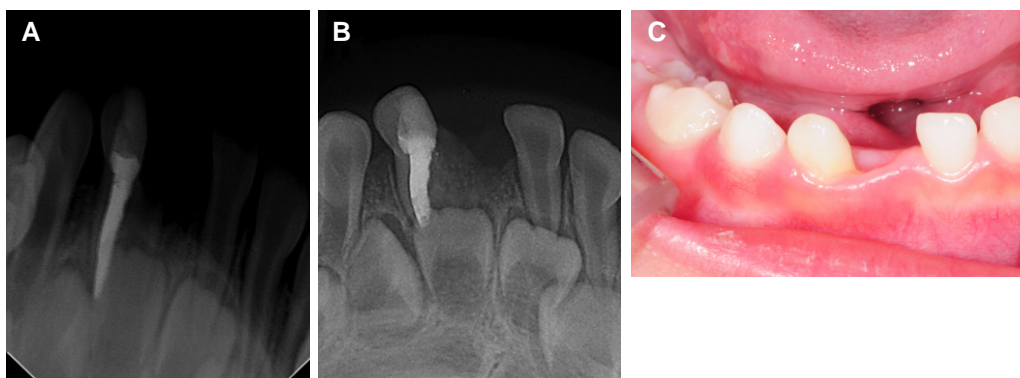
(A, B) Follow-up radiographs showing the periapical status at 3 and 6 months after canal filling, respectively. (C) Follow-up intraoral photograph showing normal healing state at the residual tooth.
